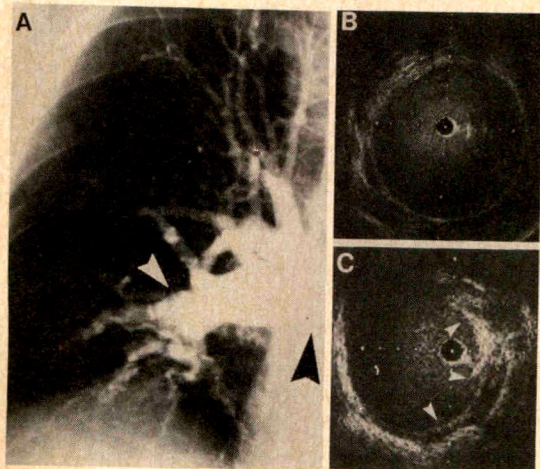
A*, angiographic images of the right pulmonary artery with a normal appearance of the main pulmonary artery (large arrow) and tapering of the inferior lobe branch (small arrow) suggesting chronic clots. *B*, intravascular ultrasound images of the main right pulmonary artery showing a normal appearance of the lumen and of the vessel wall (2 mm between dots). *C*, intravascular ultrasound images of the inferior lobe right pulmonary artery showing thickening of the vessel wall (arrows) (2 mm between dots).
